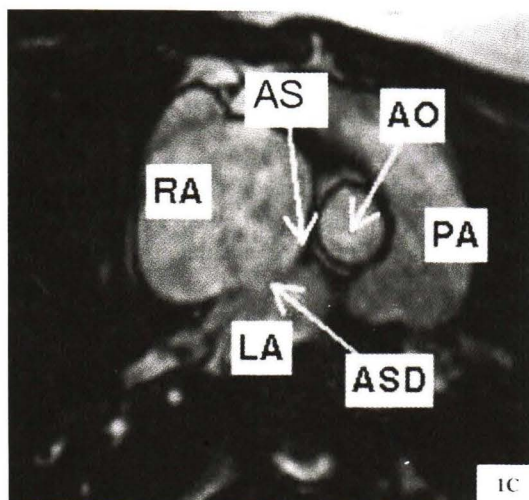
Cardiac MRI of an ASD transaortic view comparable to a parasternal short axis view of an echocardiogram.
